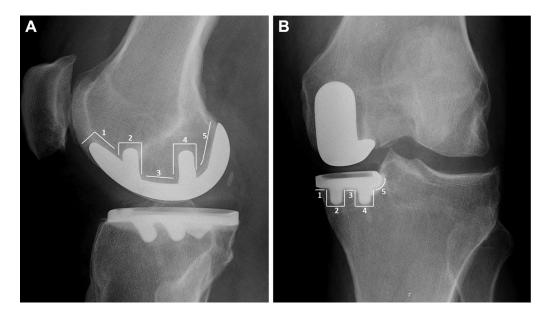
Distribution of radiolucent lines (RLL) per zone. (A) Anteroposterior radiograph, which shows RLL around the tibial component and (B) lateral radiographs, which assesses RLL around the femoral component of unicompartmental knee arthroplasty (UKA).
